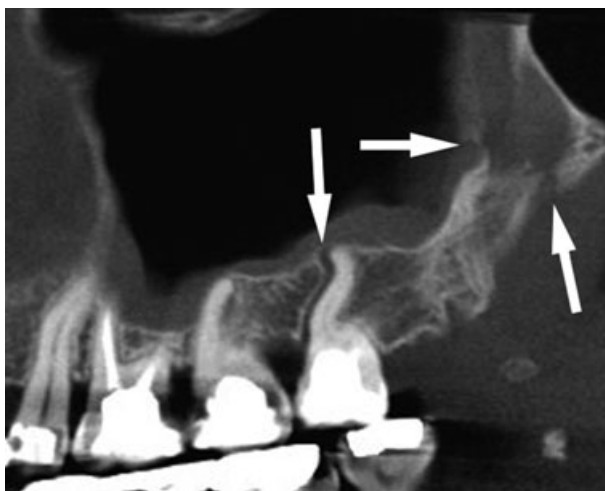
Radiological (computed tomography) evidence of fractures (arrows) in the maxillary tuberosity region. This is a large fragment.
